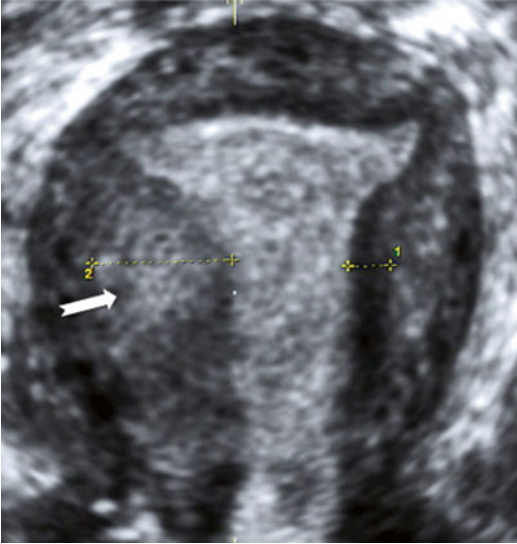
Coronal view of a uterus obtained using three-dimensional ultrasound. A focal hyperechoic infiltration and thickening of junctional zone (2) is seen on the left side (*white arrow*) and a normal junctional zone is measured on the right side (*1*)
